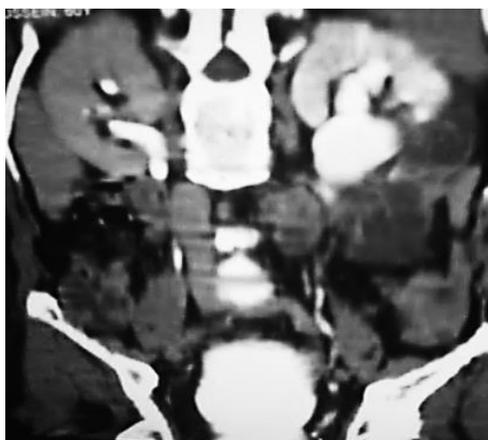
CT Urography: Incomplete Left Renal Duplication Associated with Lower Pole Segmental Cystic Dysplasia.
